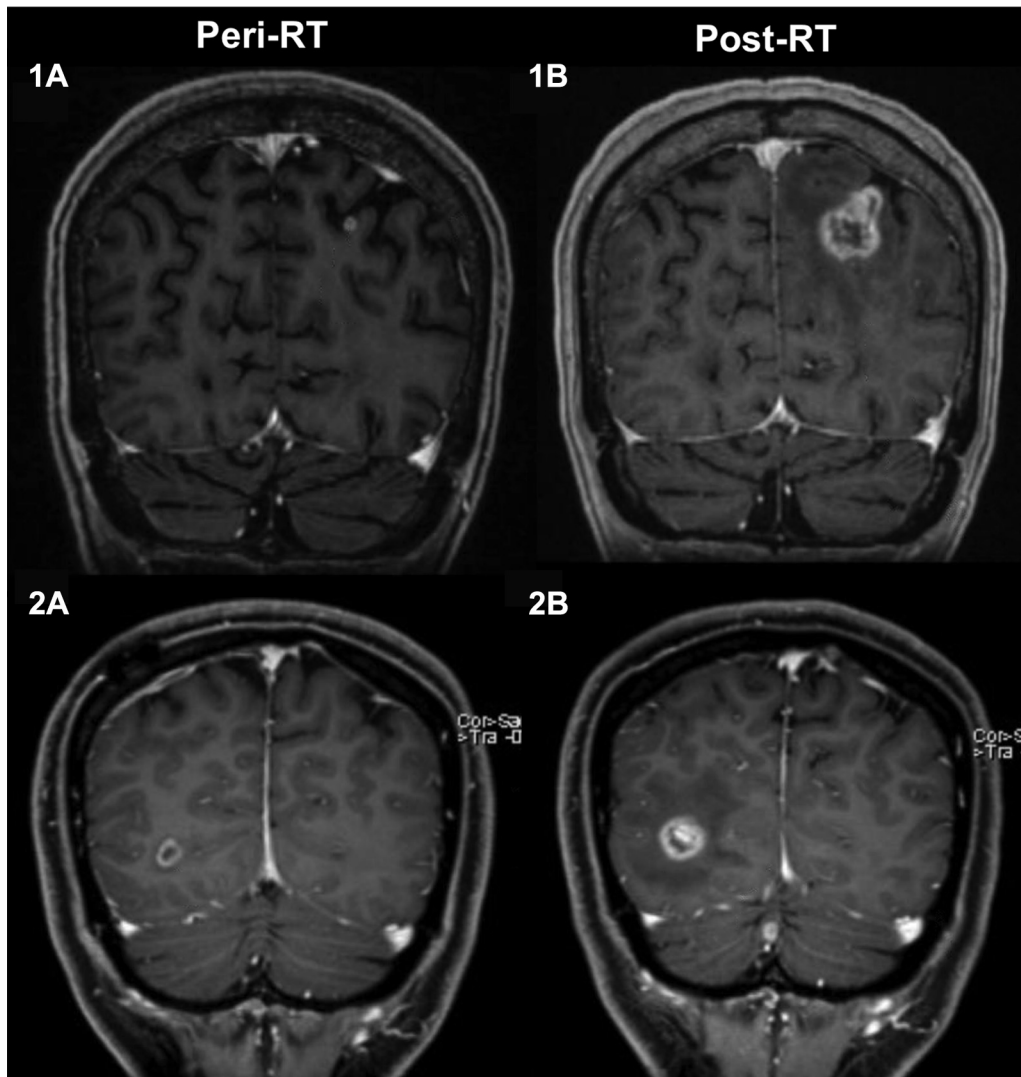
Representative axial postcontrast magnetic resonance images of pathologically confirmed radiation necrosis in an immunotherapy-naïve patient (1A/B) and an immunotherapy-treated patient (2A/B), respectively (magnetic resonance imaging sequence: 1A/B, brain volume imaging; 2A, magnetization-prepared, rapid-acquired gradient echo; 2B, stealth three-dimensional fast spoiled gradient recalled acquisition in the steady state).
